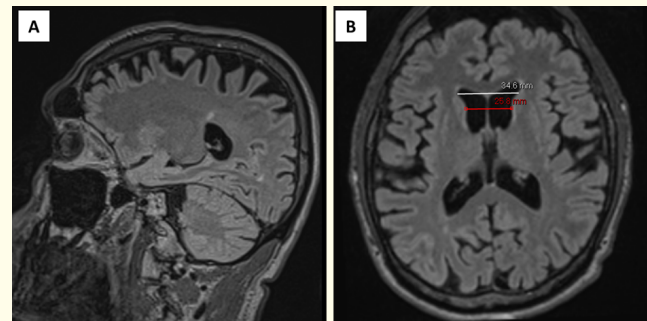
(A) Sagittal FLAIR MRI showing pericallosal and white matter hyperintensities and (B) axial FLAIR showing bilateral caudate head atrophy. Frontal horn width to inter-caudate ratio (FH:CC) is low 1.3 (normal = 2.2-2.6).
